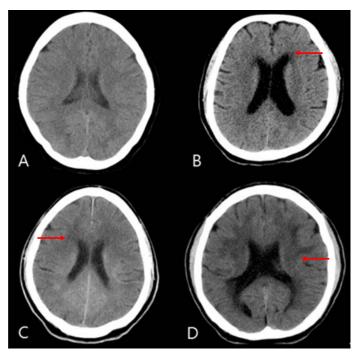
Scoring of cerebral white matter changes on brain computed tomographs. A through D, examples of progressively greater that were given score of 0, 1, 2, and 3, respectively. Zero indicates on changes. Changes are shown by arrows.
